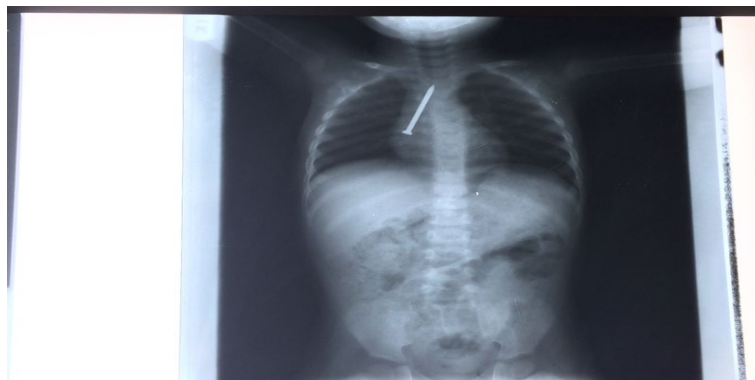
Plain chest X-ray of the patient AP view.
